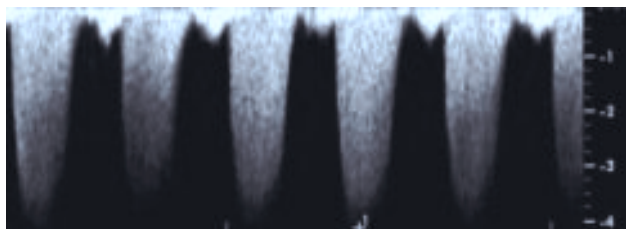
showing Continuous wave Doppler of tricuspid regurgitation. The regurgitant jet is characterized by turbulent flow depicted by a full Doppler envelope (upper panel). The peak velocity of the regurgitant jet was 4.0 m/s, resulting in a pressure gradient of 64 mmHg.
